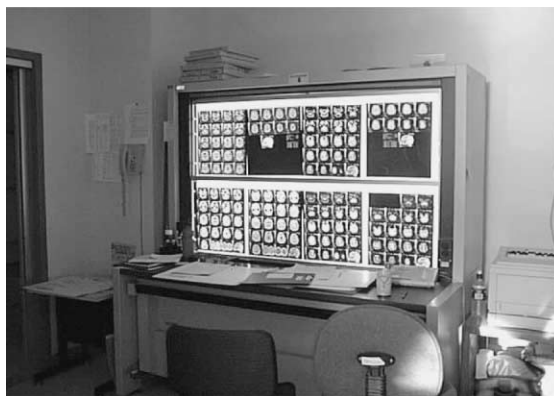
The traditional light screen used by radiologists to display MR images.
